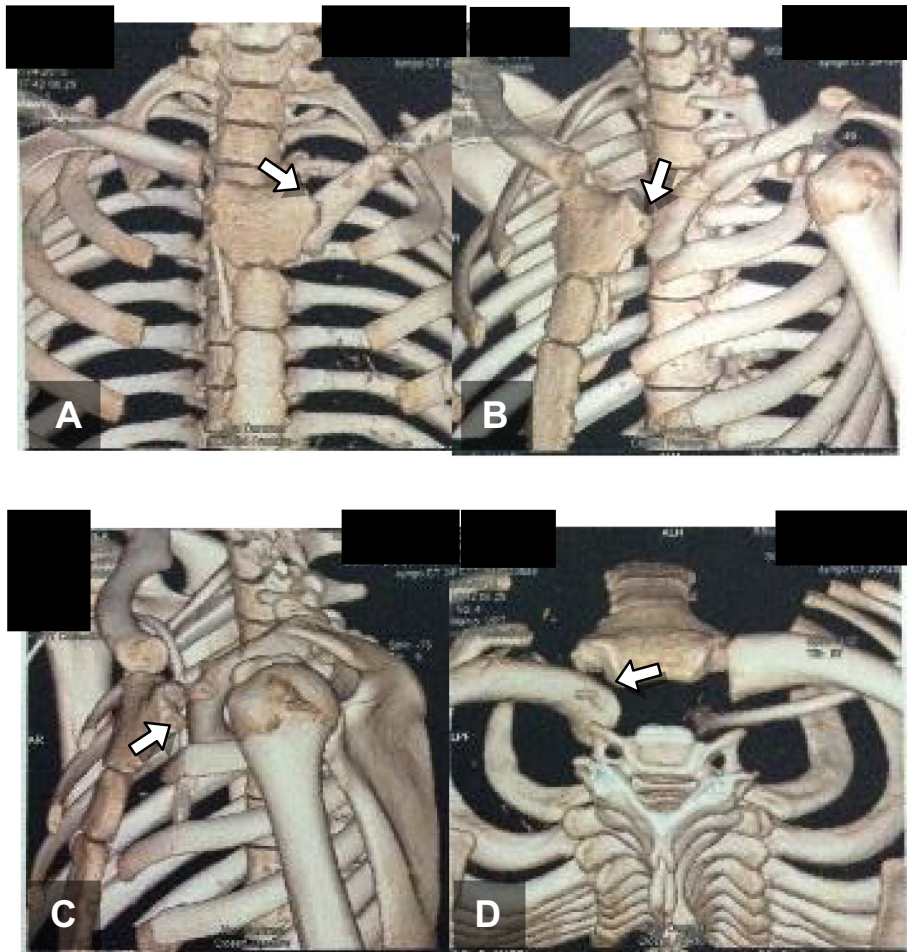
CT-scan with 3D reconstruction clearly demonstrated the severity of inferior and posterior displacement of the medial end of left clavicle (arrows).
